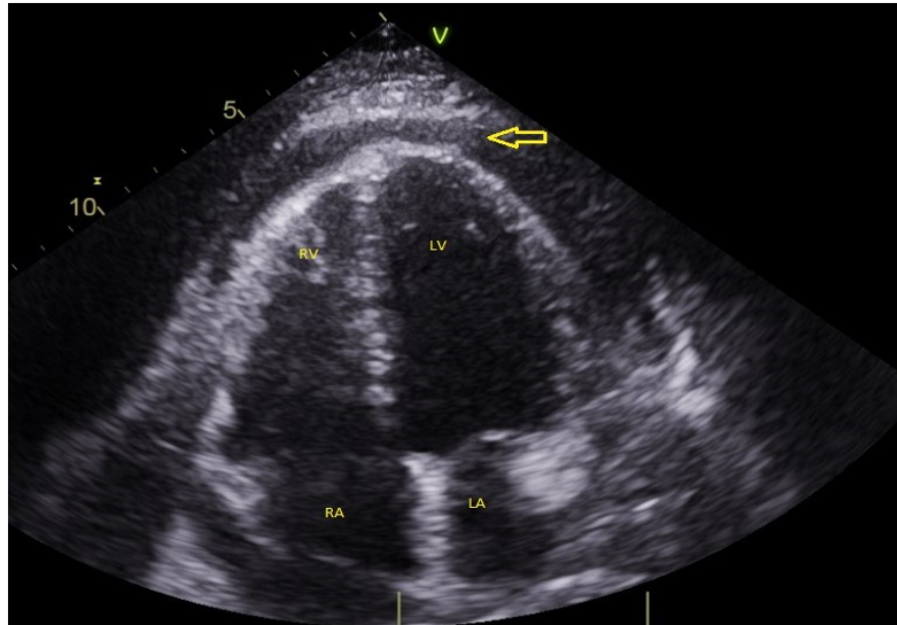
Transthoracic echocardiogram (apical 4 chamber view) demonstrates large pericardial effusion (arrow).
